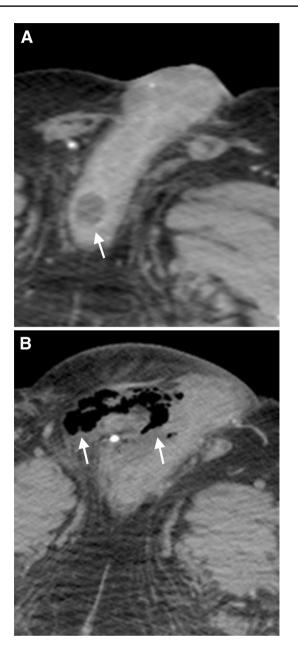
Fournier gangrene secondary to a cavernosal abscess. a Axial enhanced CT image shows a small cavernosal abscess (arrow). b Axial enhanced CT image in the same patient obtained 3 months later shows progression of the abscess into Fournier gangrene (arrow)
